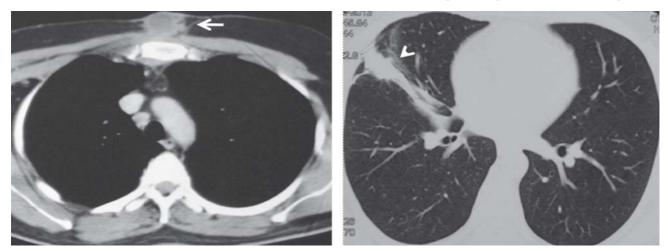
Contrast enhanced computed tomography done in 2015 after 6 months of treatment showing resolution of the cutaneous nodules (white arrow) and pulmonary infiltrates (white arrowhead).
